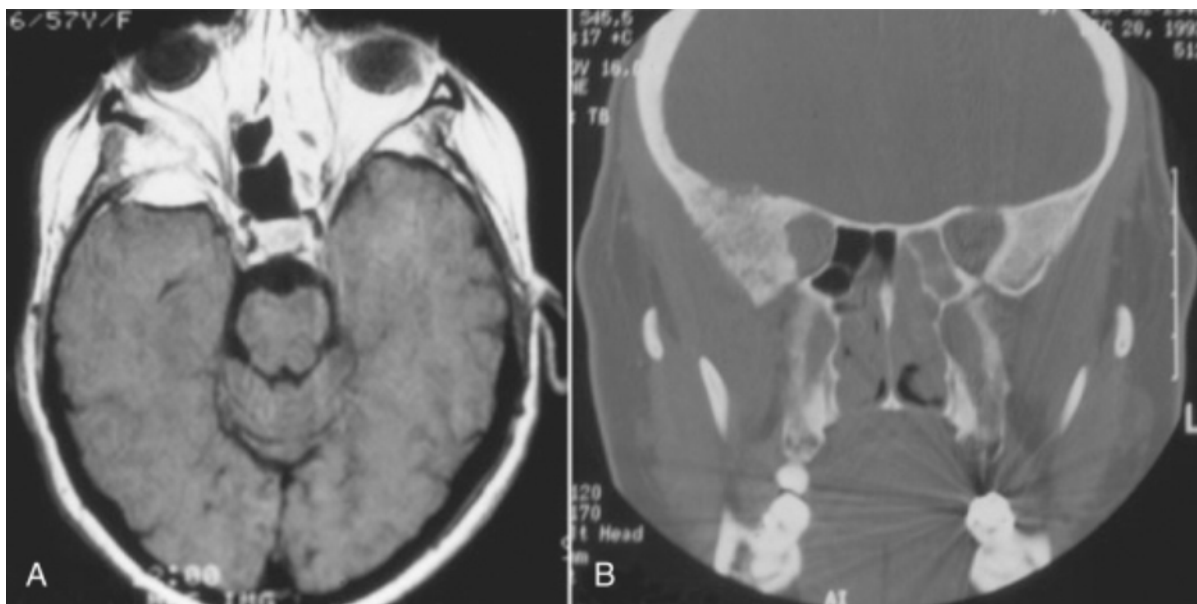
Magnetic resonance image (A) and computed tomography scan (B) demonstrating a meningioma involving the lateral wall of the orbit with extension to the orbital apex and middle cranial fossa. If the patient has permanent visual loss as a result of such a tumor, a transorbital approach may be used.
